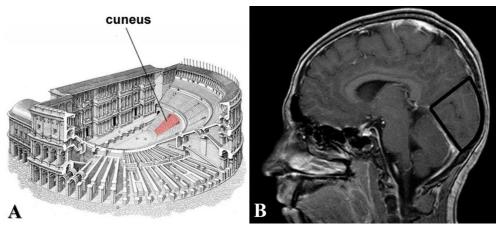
One of a set of wedge-shaped divisions separated by stairs in the Ancient theatre, called cuneus (A). Sagittal MRI image showing the cuneiform lobe (black frame) (*Assoc. Prof. Dr. M. D. Turliuc's personal collection*) (from *Turliuc et al., 2017a*) (B).
